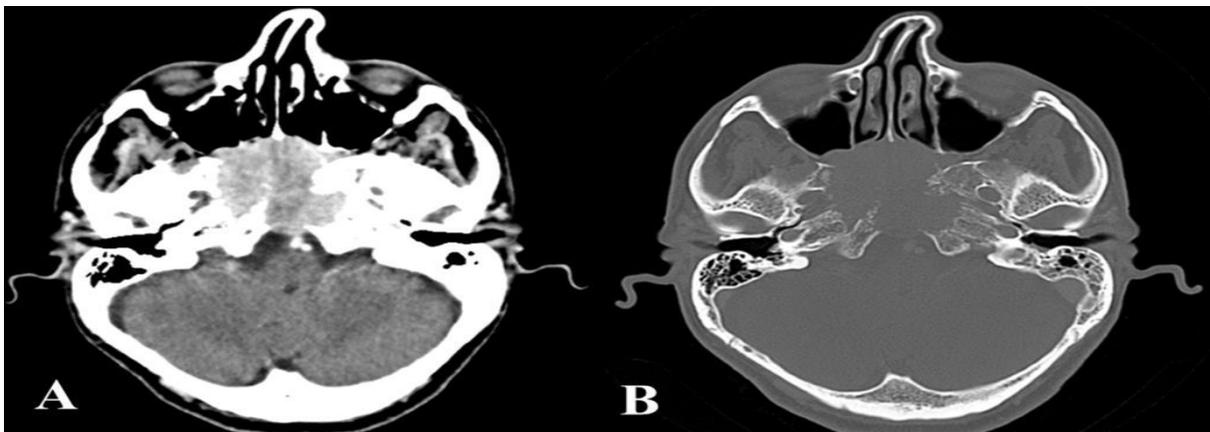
Axial contrast-enhanced CT images: A. Hyperdense tumor is seen (captures the contrast substance) invading the skull base; B. Bone window CT images show bone destruction of skull base (Turliuc *et al.*,2016c).
